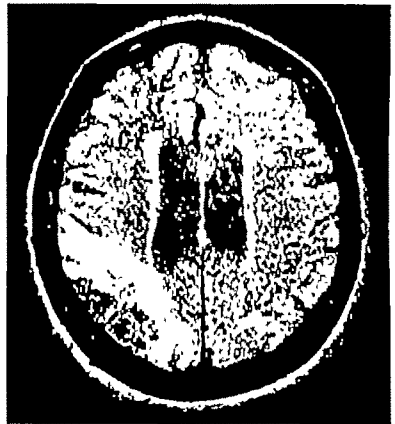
MRI scan demonstrating an area of infarction involving the right posterior inferior parietal region
